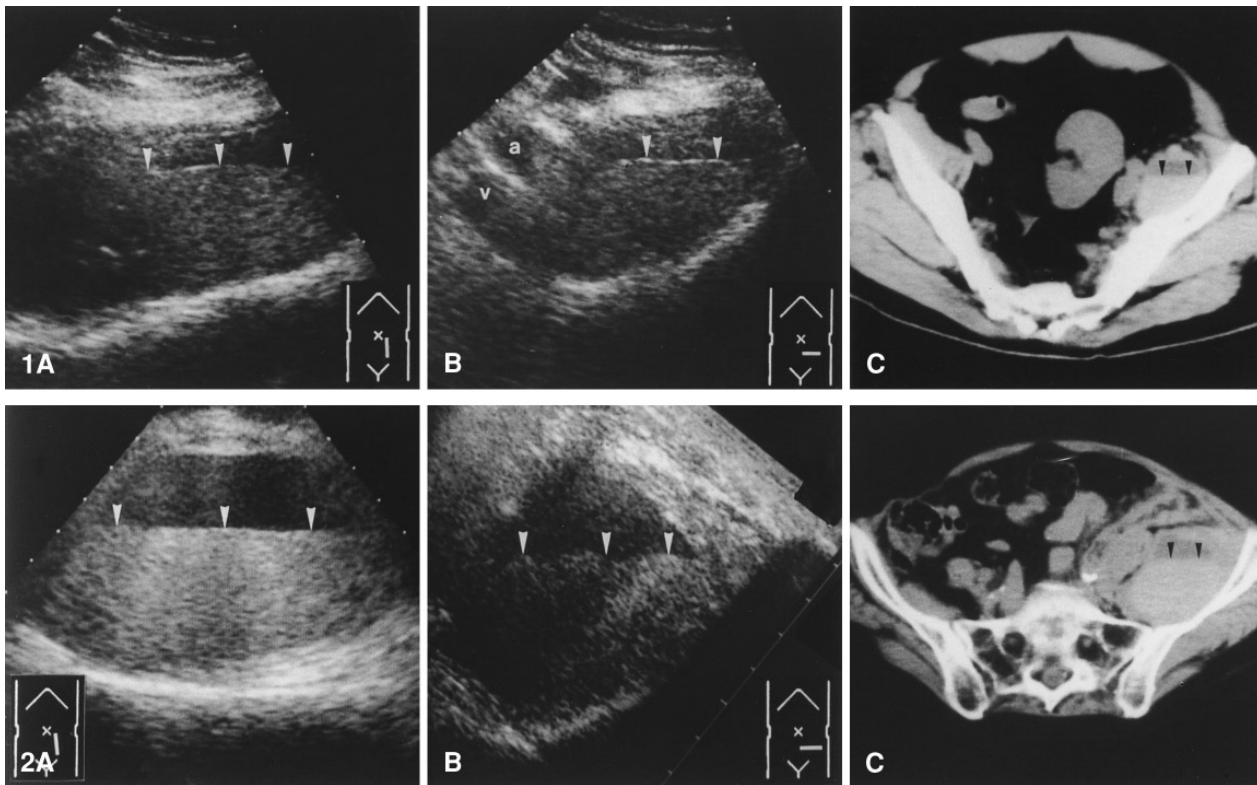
Longitudinal (A) and transverse (B) ultrasound images of a left-sided iliopsoas hematoma. The fluid–debris interface indicates a liquefied hematoma. C CT scan, corresponding with that in B, confirms the hematoma containing sedimented hyperdense material (arrowheads). a, iliac artery; v, iliac vein.
